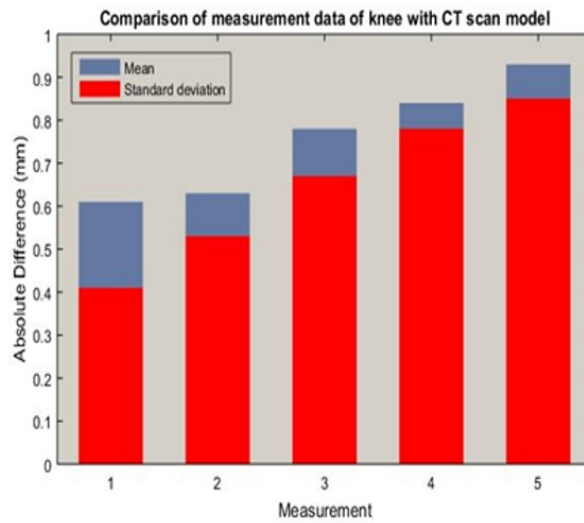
Comparison of measurement data of knee with CT scan model [3]
